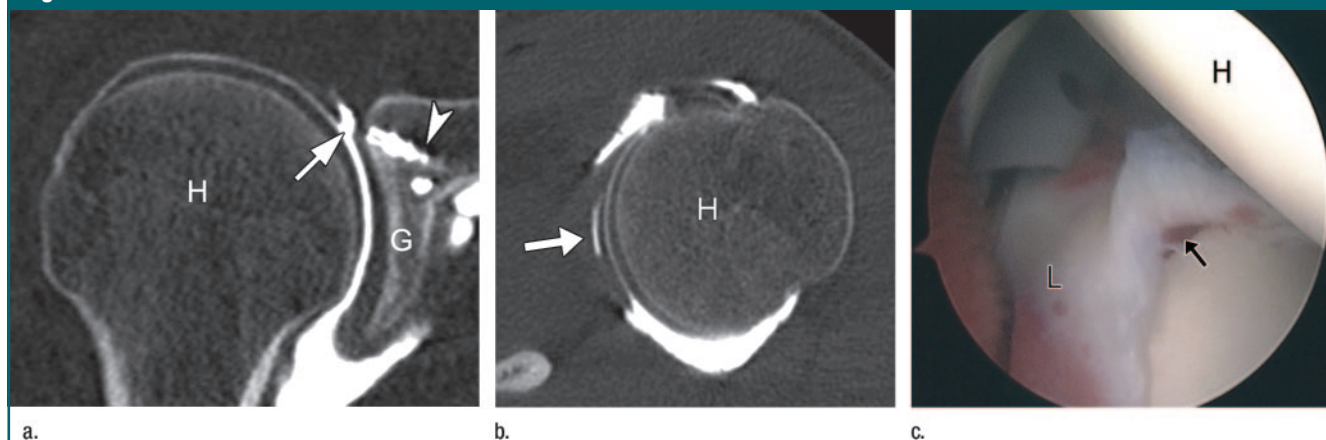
Type II SLAP lesion correctly diagnosed with multidetector CT arthrography in 28-year-old man. H = humeral head. (a) Coronal oblique multidetector CT arthrogram shows lateral extension of contrast medium (arrow) into superior labrum. Arrowhead = metal anchors, G = glenoid labrum. (b) Axial multidetector CT arthrogram shows anterior-to-posterior extension of contrast medium (arrow) into superior labrum. (c) Arthroscopic view from posterior portal confirms presence of type II SLAP tear (arrow). L = labrum.
